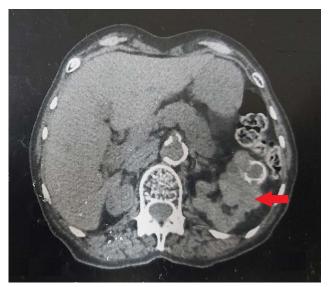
Abdominal contrast-enhanced computed tomography showing a left kidney, with multiple masses with annular calcifications, with an inferior polar mass showing a central scar (red arrow).
